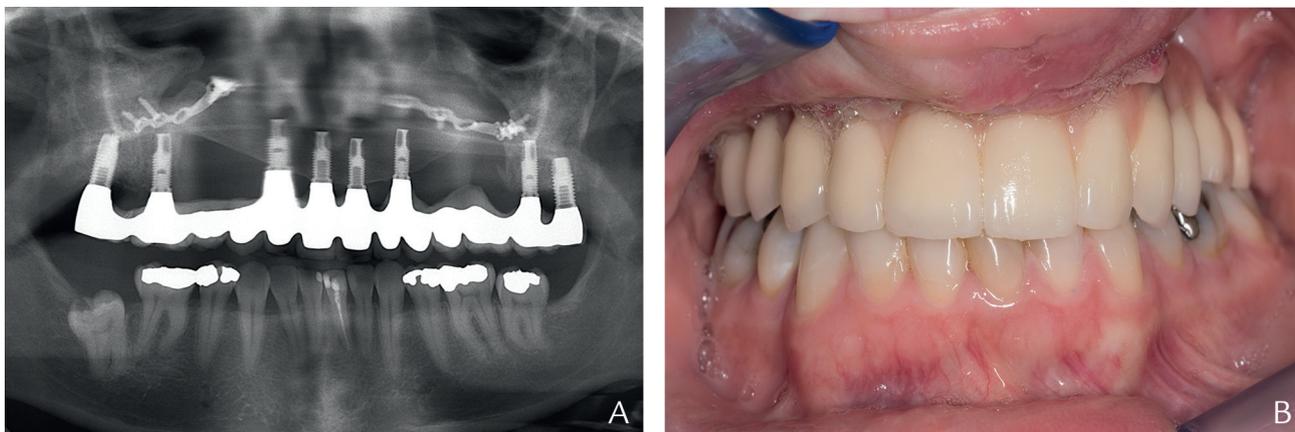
A, Panoramic radiograph of 1-piece fixed metal-ceramic prosthesis with stable occlusion. B, Frontal centric occlusal view of definitive prosthesis.
